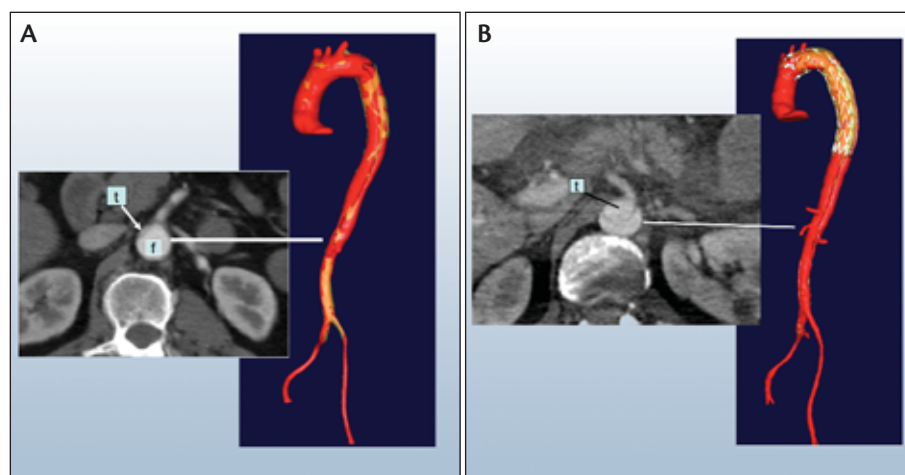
M2S reconstruction (M2S, Inc., West Lebanon, NH) of the thoracoabdominal aorta showing the descending aortic dissection with near occlusion of the true lumen (t) in the visceral segment as shown on the centerline computed tomographic (CT) image at the level of the superior mesenteric artery, producing abdominal and peripheral ischemia (f, false lumen) (A). M2S reconstruction of the thoracoabdominal aorta 2 days after deployment of a Valiant Thoracic Stent Graft (Medtronic, Inc., Minneapolis, MN) showing partial expansion of the true lumen (t) with reperfusion of the visceral arteries and reconstitution of flow to the lower extremities (B).
